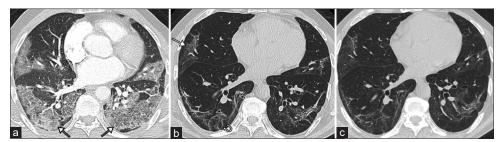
A 66-year-old male with COVID-19 pneumonia. (a) Axial contrast-enhanced chest CT image demonstrates acute lower-lobe predominant bilateral ground-glass opacities (arrows). (b) Axial noncontrast chest CT image performed 1 month later demonstrates substantially improved ground-glass opacities (white arrow), new superimposed curvilinear opacities (curved arrow), and reticulation (white arrowhead), associated with mild architectural distortion and traction bronchiectasis (black arrowhead), consistent with mild pulmonary fibrosis. (c) Axial noncontrast chest CT image performed 6 months after initial CT shows unchanged mild fibrosis. CT: Computed tomography
